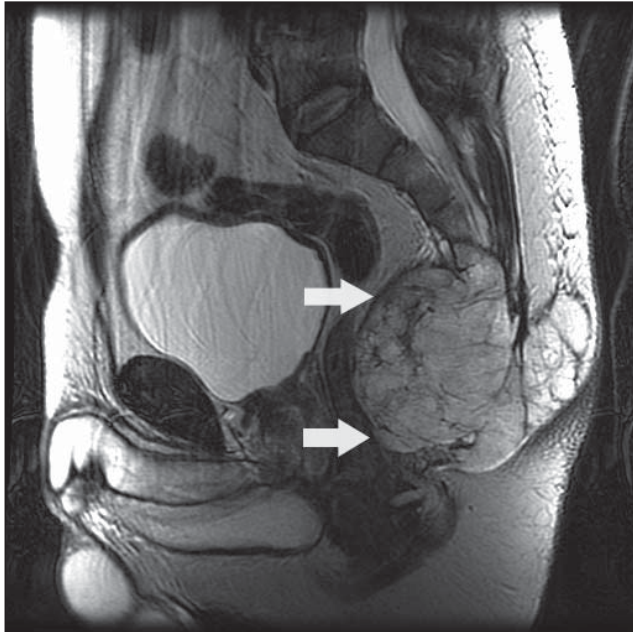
Sagittal T2 weighted unenhanced fast spin echo MRI – arrows indicate anterior border of mass.
